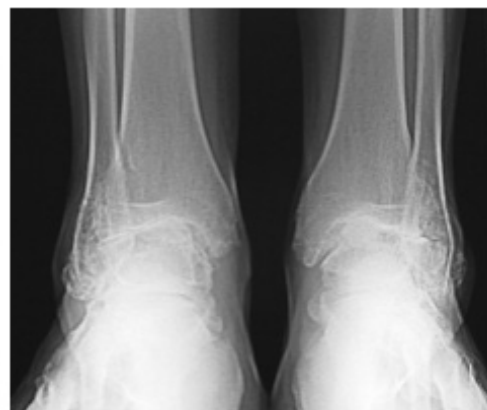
frontal X-ray image of the ankle joint (Ankle Arthritis | Dr. Mike Smith | Orthopaedic Ankle Surgeon | Adelaide, n.d.)
